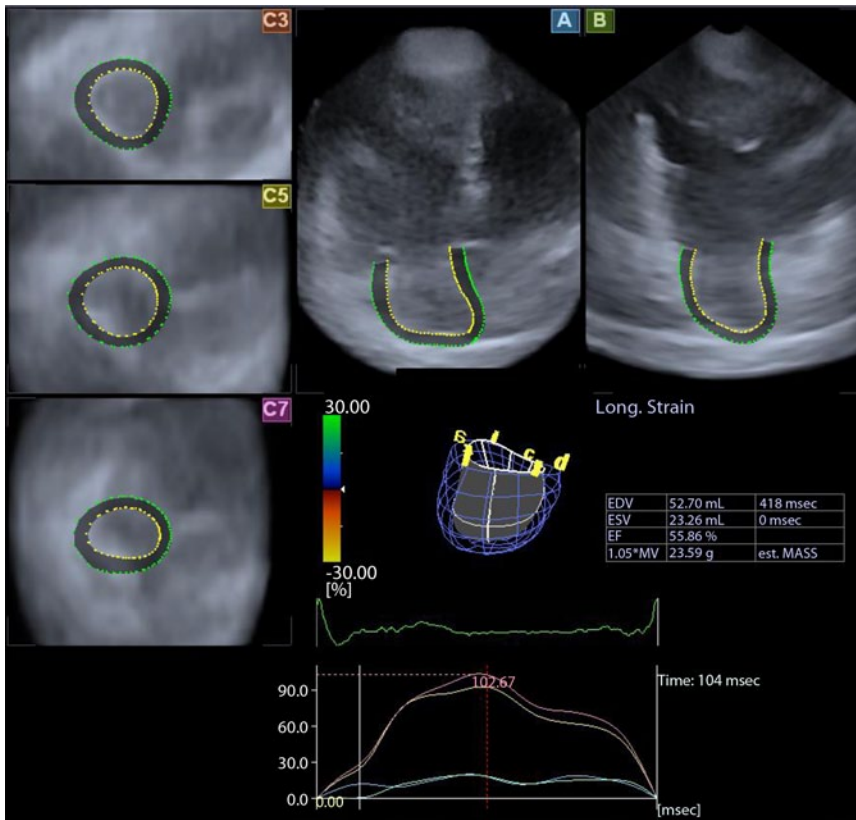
▲ Images from three-dimensional full-volume dataset demonstrating the right atrium in a patient with corrected tetralogy of Fallot: (A) apical four-chamber view, (B) apical two-chamber view, (C3) parasternal short-axis view at basal, (C5) mid-, and (C7) superior right atrial level. Three-dimensional cast of the right atrium and calculated parameters based on three-dimensional speckle-tracking echocardiographic analysis are also presented.
